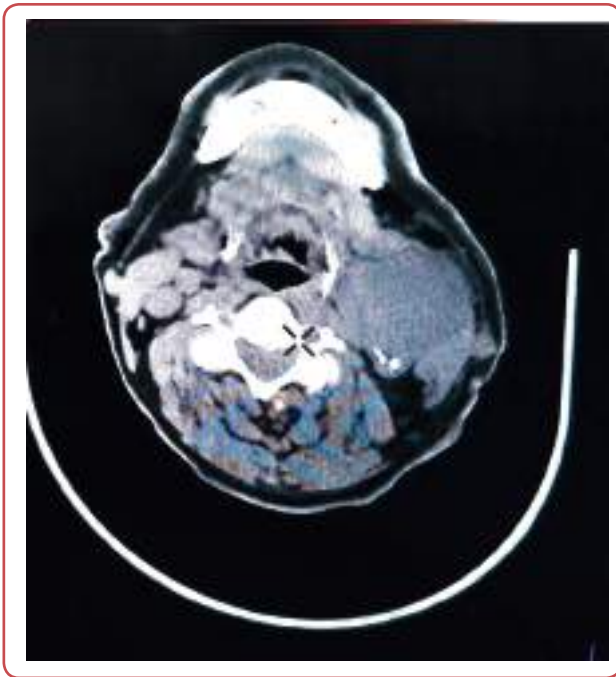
Plain computed tomography (CT) neck showing a soft tissue density lesion in the left anterior triangle region. No intralesional calcifications were seen.
